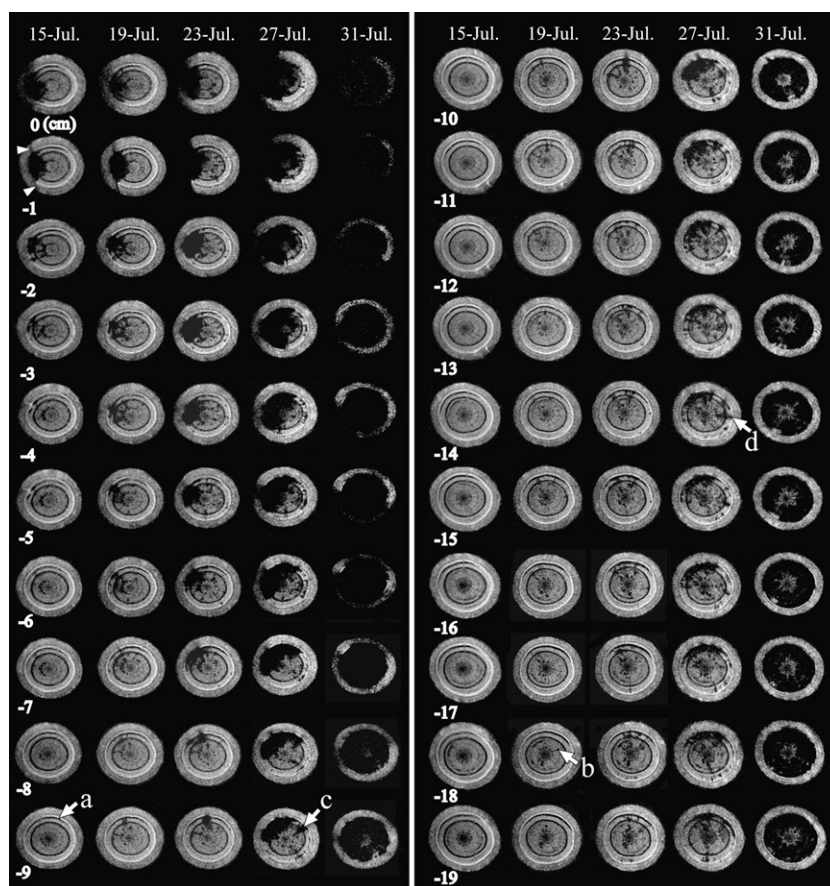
Cross-sectional MR images acquired from interval positions of 1 cm pitch within the monitoring region of the 1-year-old stem of the control tree after injection with distilled water. MRI parameters were as follows: repetition time = 500 ms, echo time = 19 ms, slice thickness in the axial direction = 1 mm. The arrowhead indicates injury by knife. The small arrow indicates newly made tissue that originated in the cambium. The large arrows indicate the embolism that was made within latewood of the injection site in the current year.
